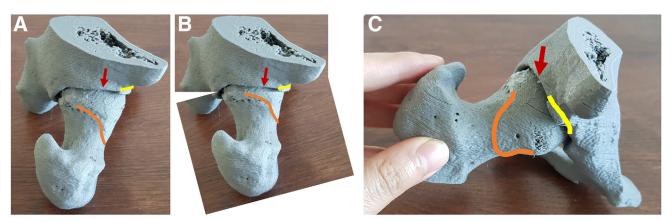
(A) Three-dimensional printed hip model using the patient's own computed tomography scan. The tactile model is used preoperatively to define the extent of the cam lesion. The red arrow estimates 12-o'clock position as viewing from the midanterior portal, the yellow line represents the boundary of an os acetabuli fracture, and the orange line represents the extent of the cam impingement. This shows the ability of a 3D-printed model to capture the anatomical structure of a patient's cam lesion for future surgical resection. (B) Three-dimensional printed hip model using the patient's own computed tomography scan, displaying the cam impingement running parallel with the acetabulum positioned at approximately 15° of forward flexion. The red arrow estimates 12-o'clock position as viewing from the midanterior portal, the yellow line represents the boundary of an os acetabuli fracture, and the orange line represents the extent of the cam impingement. Creating a parallel line of the cam impingement to the acetabulum allows for a standardization of viewing in order to mark the cam lesion intraoperatively. (C) 3Dprinted hip model using the patient's own computed tomography scan. Viewing anteriorly, the anteromedial aspect of the cam can be appreciated. The red arrow estimates 12-o'clock position as viewing from the midanterior portal, the yellow line represents the boundary of an os acetabuli fracture, and the orange line represents the extent of the cam impingement. This represents the expected view of the lesion intraoperatively from the midanterior portal. (3D, 3-dimensional.)
